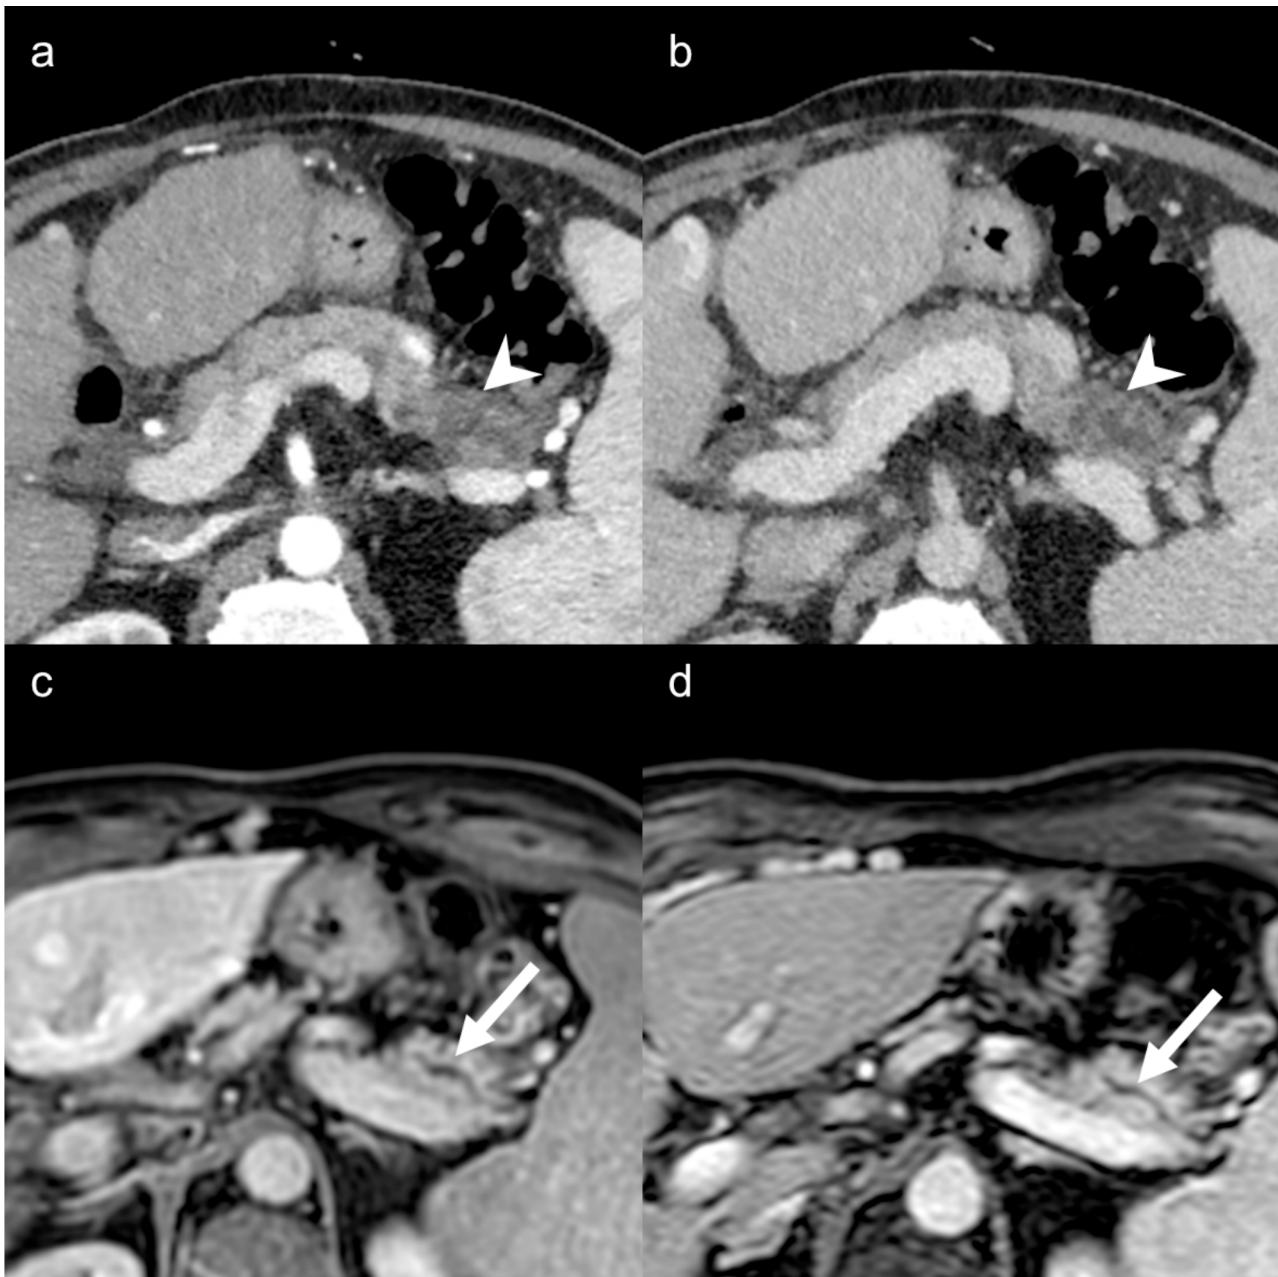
75-year-old male with pancreatic ductal adenocarcinoma in the tail. Contrast-enhanced CT on arterial (a) and portal-venous (b) phases show a hypovascular pancreatic lesion in the tail (arrowheads). Contrast-enhanced MRI acquired 12 months (c) and 18 months (d) before demonstrated focal dilation of the main pancreatic duct (arrows).
